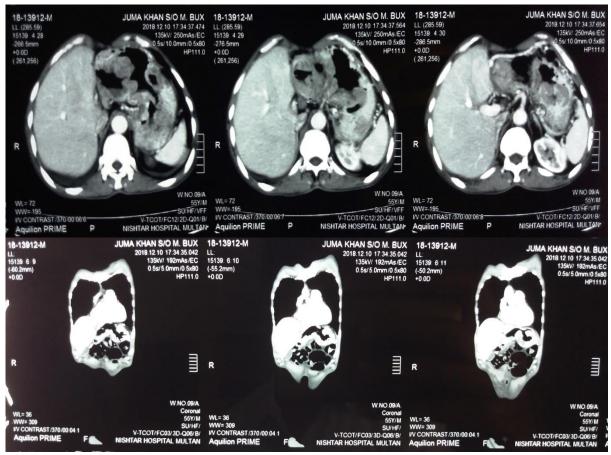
Axial contrast-enhanced CT images of the abdomen demonstrate significant circumferential and asymmetric wall thickening involving the fundus and body of the stomach, predominantly along the posterior wall, extending toward the antrum. Multiple enlarged perigastric and porta hepatis lymph nodes are visible, along with minimal ascites. These findings are suggestive of an aggressive infiltrative neoplasm.
